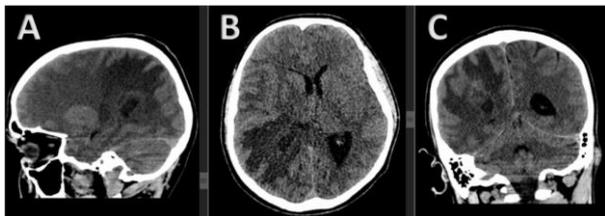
Initial Brain CT scan without contrast showing one nodular lesion in the right hemisphere on sagittal (A), axial (B) and coronal (C) planes. Perilesional digitiform oedema shown in the blue circle.
